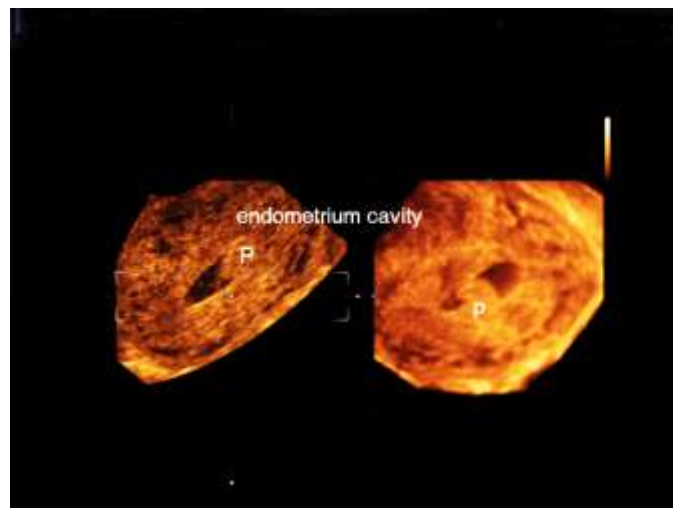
2D and 3D ultrasound surface rendering of small endometrial polyp.
